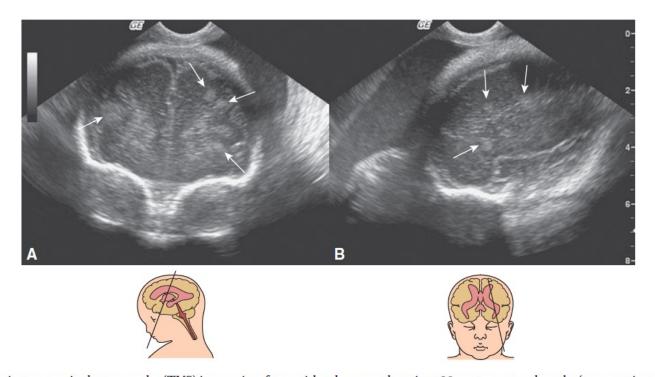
Brain transvaginal sonography (TVS) images in a fetus with tuberous sclerosis at 28 postmenstrual weeks (same patient as in Figure 7–14) show multiple parenchymal echogenic nodules (*arrows*). (A) Coronal section at the level of the frontal horns. (B) Paramedian section lateral to the lateral ventricle.
